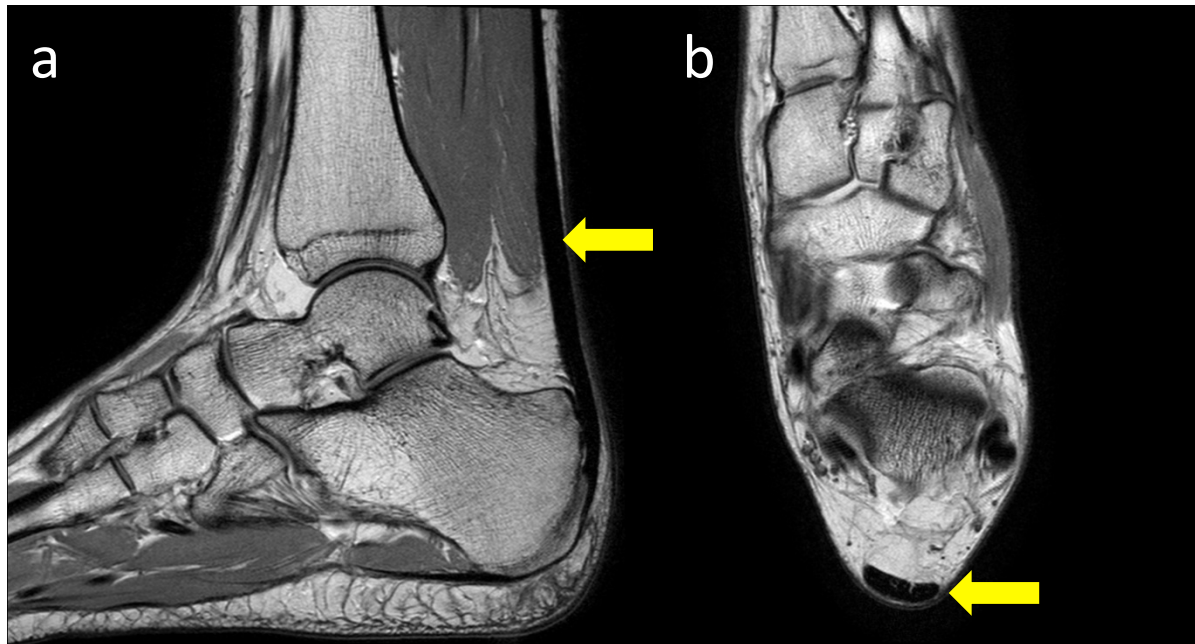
Magnetic resonance imaging of the normal Achilles tendon. (a) Sagittal and (b) Axial Proton-density sequence MR image showing a normal Achilles tendon (arrow) with uniform thickness and predominantly low signal intensity
